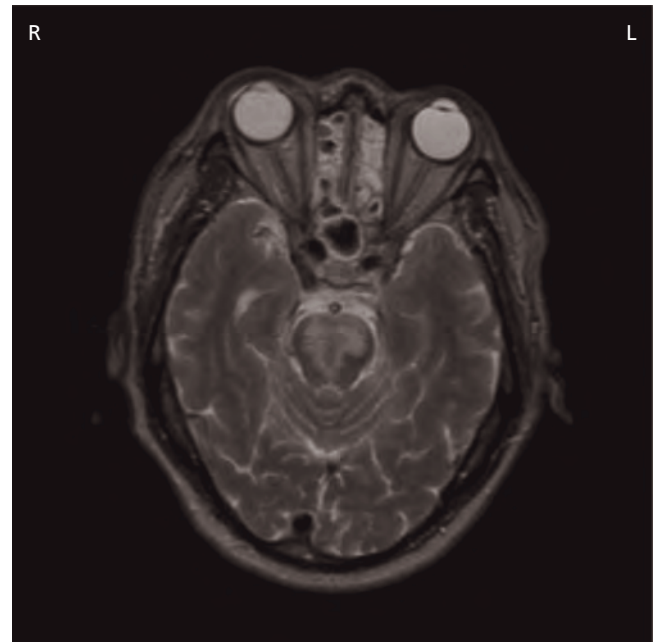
Extensive pontine infarction due to vertebrobasilar occlusion in a patient with locked-in syndrome (MRI T2W).
